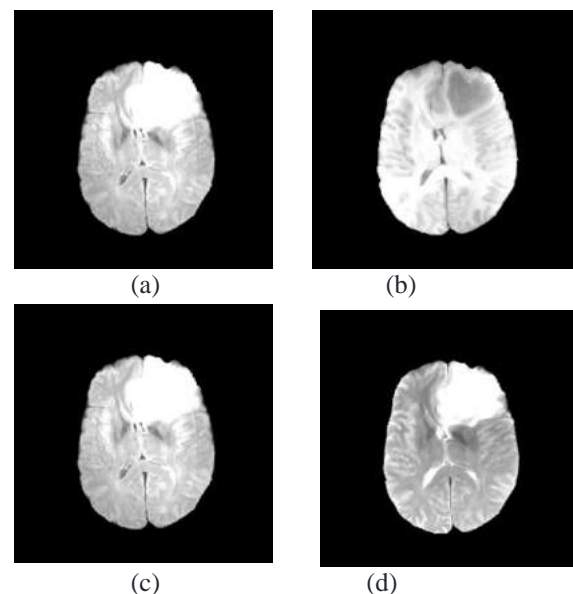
Four different modalities of MRI of a HGG patient (a) Flair, (b) T1, (c) T1c and (d) T2
